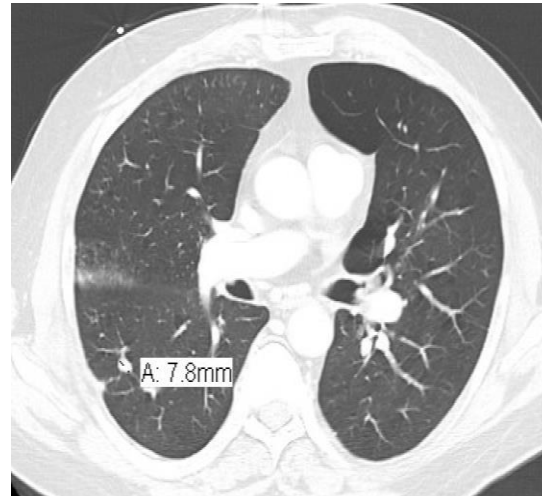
Image (a) Axial CT – Imaging of chest demonstrating focal cavitary lesion.
